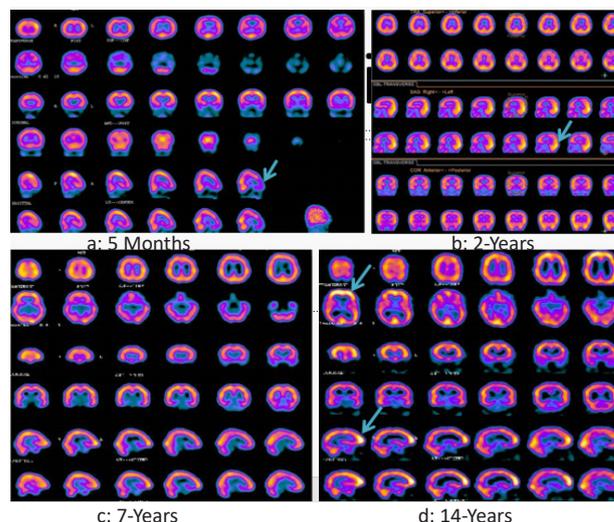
SPECT brain scan: Normal variation of rCBF per age: (a) Decreased uptake in frontal lobe (arrow) at age of 5 months. (b) Increased uptake in occipital lobe (arrow) and normalization in frontal lobe in a 2 year old. (c) Homogeneous uptake in cerebral cortex in a 7 year old. (d) Increased uptake in frontal lobe (arrow) in a 14 year old (adolescent age).
